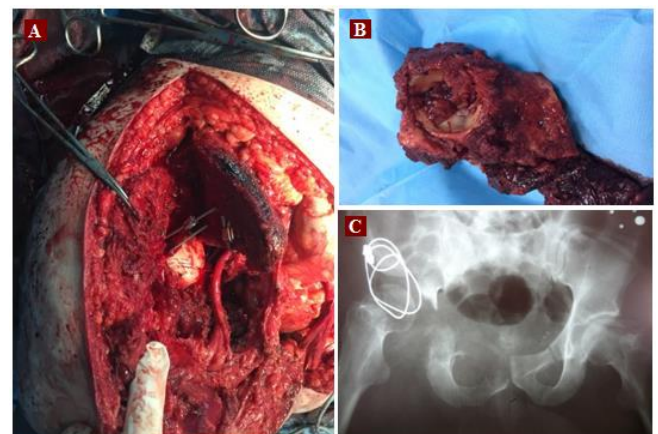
MC, A) Resection zone II Femuro-iliac Reconstruction B) resected tumoral mass C) Postoperative X-ray
